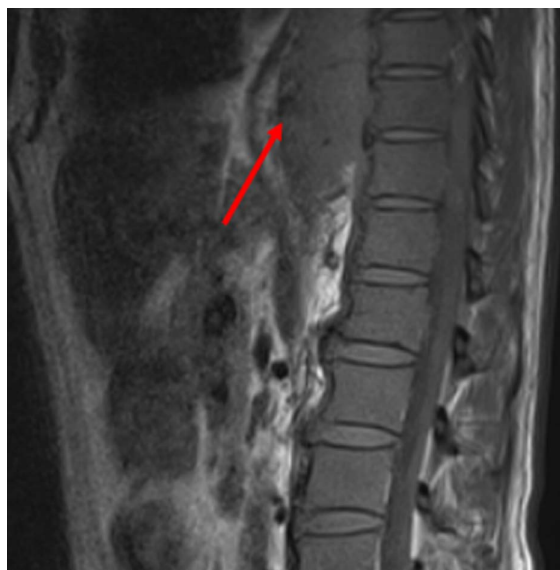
The MRI examination showed anterior spinal neoplastic lesions in the posterior mediastinum.
